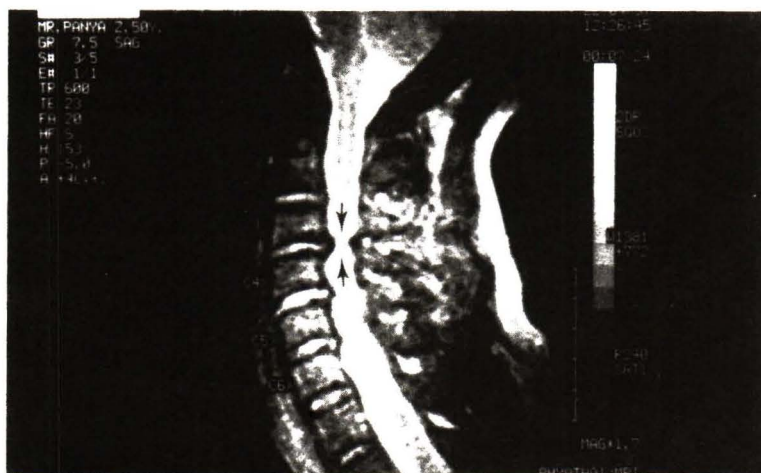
MRI in a case of cervical spondylotic myelopathy of C₃₋₄.
